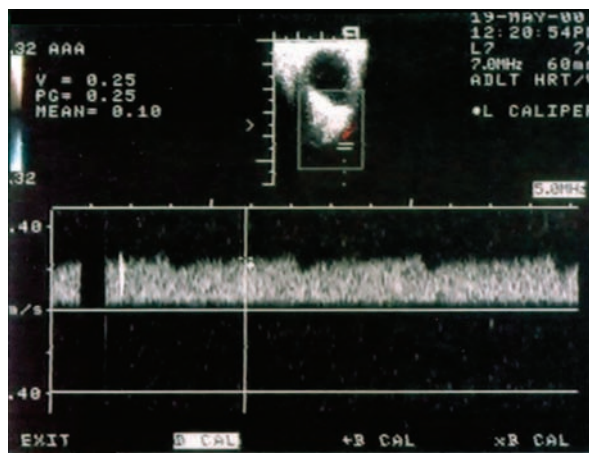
Color Doppler imaging of the ophthalmic artery during antegrade selective cerebral perfusion. A relatively nonpulsatile spectral signal was detected with blood flow velocity above 20 cm/sec.
